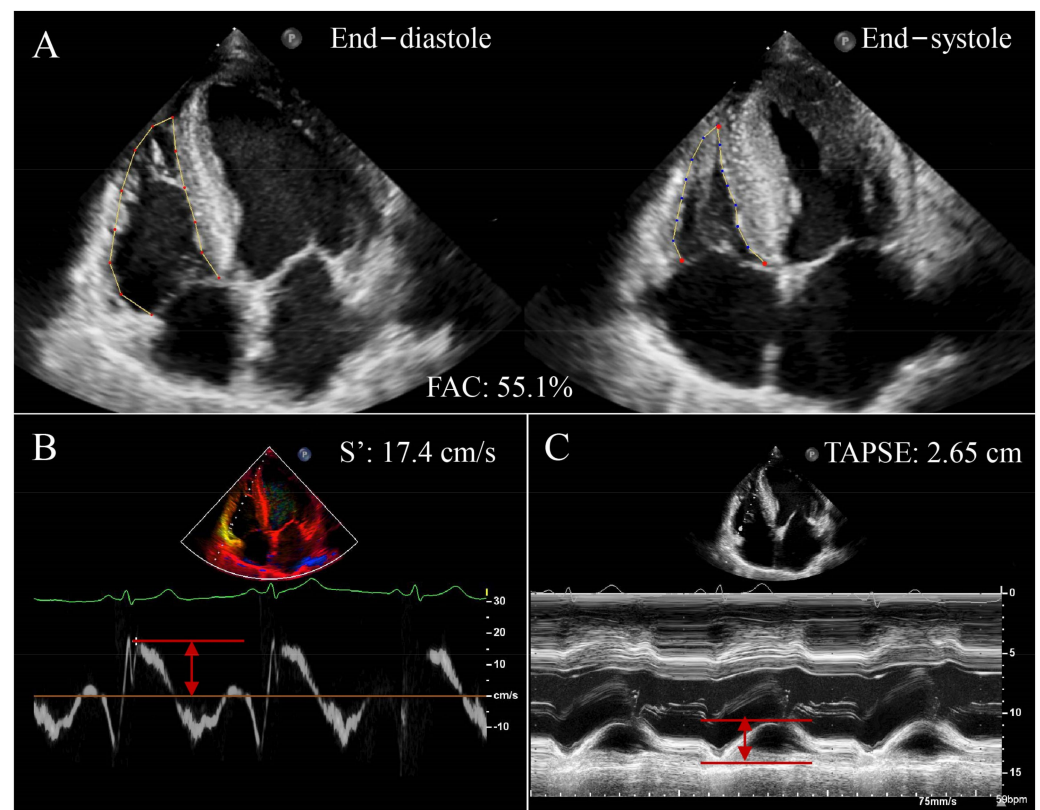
Conventional RV function parameters using two-dimensional echocardiography in a patient with HFrEF. (A) RVFAC; (B) S' ; (C) TAPSE; RV, right ventricular; HFrEF, heart failure with reduced ejection fraction; RVFAC, right ventricular fractional area change; S' , tricuspid annular systolic velocity; TAPSE, tricuspid annular plane systolic excursion. Red arrows represent measurements for parameters.
